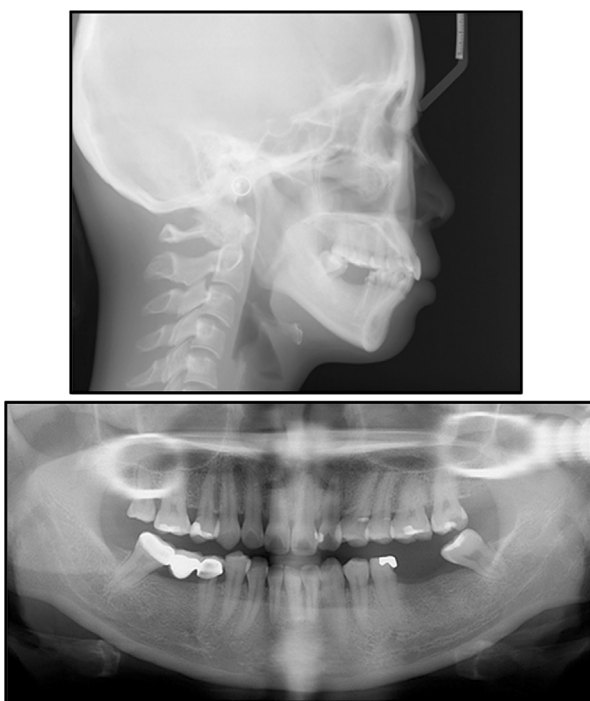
Pretreatment cephalometric (*above*) and panoramic (*below*) radiographs.
